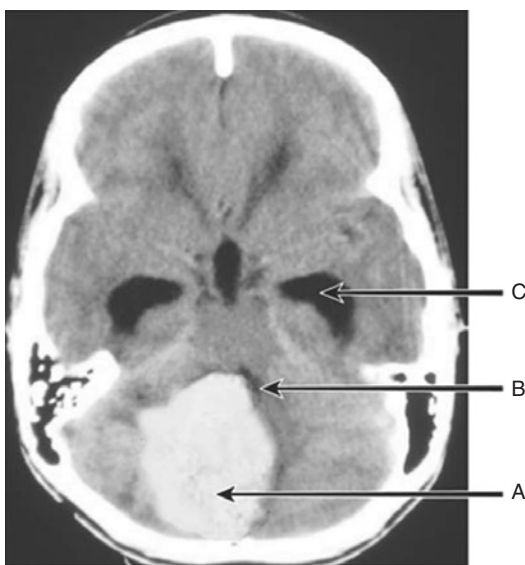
A non-contrast CT scan showing a large cerebellar hematoma (A) causing almost complete compression of the fourth ventricle (B) with obvious hydrocephalus seen in the dilated temporal horns (C)
